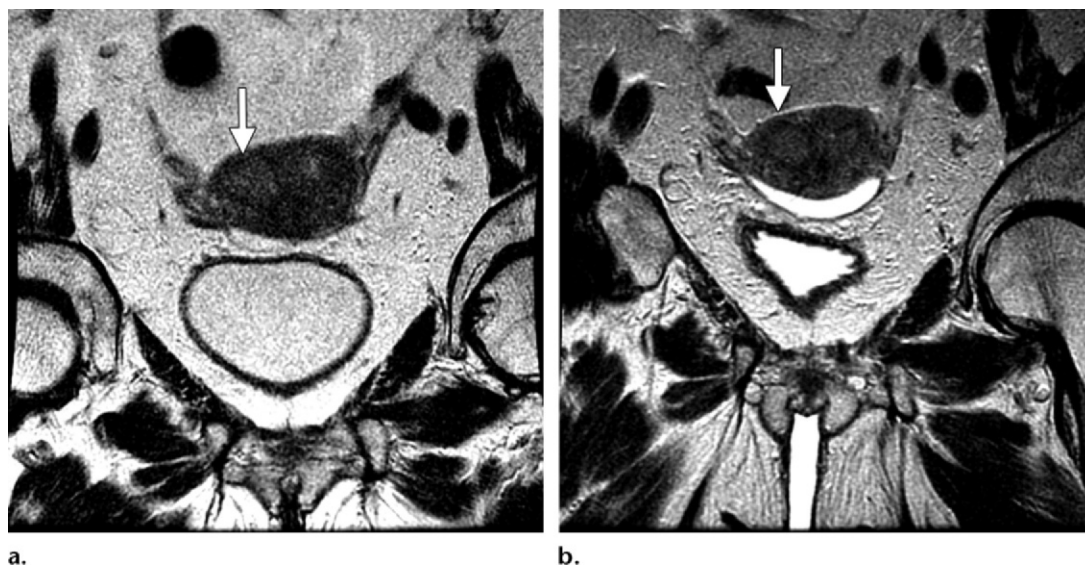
Poor SNR may be improved by increasing FOV. (a) Coronal high-resolution T2-weighted FRFSE MR image obtained at the level of the pelvis (FOV, 18 cm) poorly depicts an endometrial tumor (arrow), a result of poor SNR. (b) Coronal high-resolution T2-weighted FRFSE MR image obtained with a larger FOV (20 cm) shows the tumor expanding the endometrial cavity (arrow). This simple step doubles the SNR.
